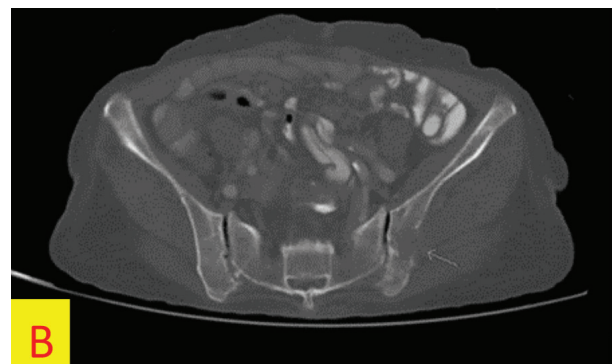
CT scan of whole abdomen
